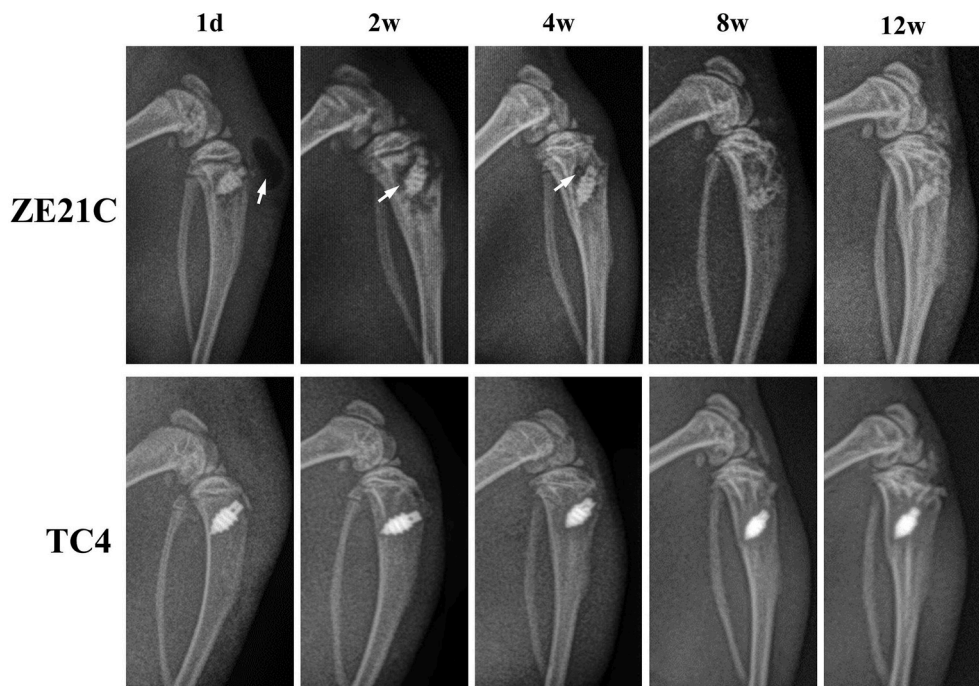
Representative radiographic images at 1 day, and 2, 4, 8, and 12 weeks after implantation. White arrows: gas shadow.
